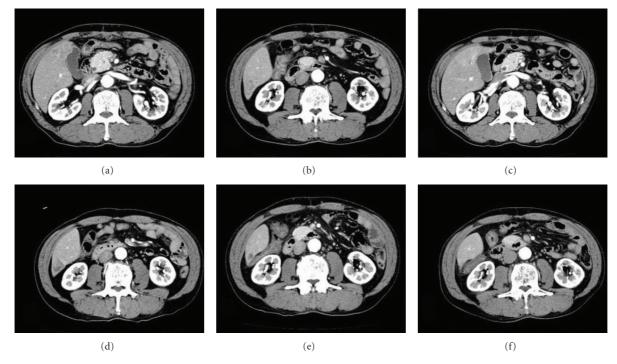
Abdominal computed tomography (CT) findings. (a)-(b) CT scan before chemoradiotherapy showing multiple liver metastases in S5 and S6. (c)-(d) CT scan after 5 cycles of S-1 administration showing disappearance of the tumor in S5, while tumor was still visible in S6. (e) CT scan after radiation and 10 cycles of S-1 administration showing reduction of tumor in S6. (f) CT scan after radiation and 15 cycles of S-1 administration showing disappearance of liver metastasis; hence, this case was interpreted as a complete response.
